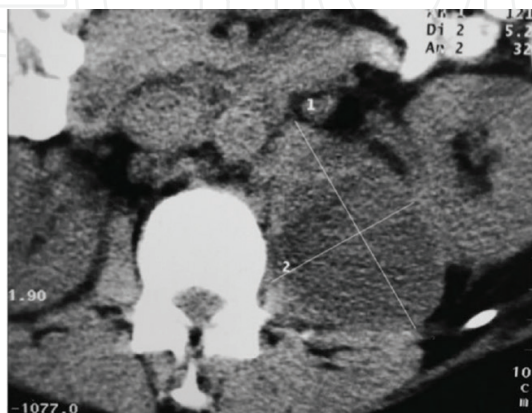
Axial CT revealing involvement of left psoas muscle and para-aortic space with displacement of the left kidney.
